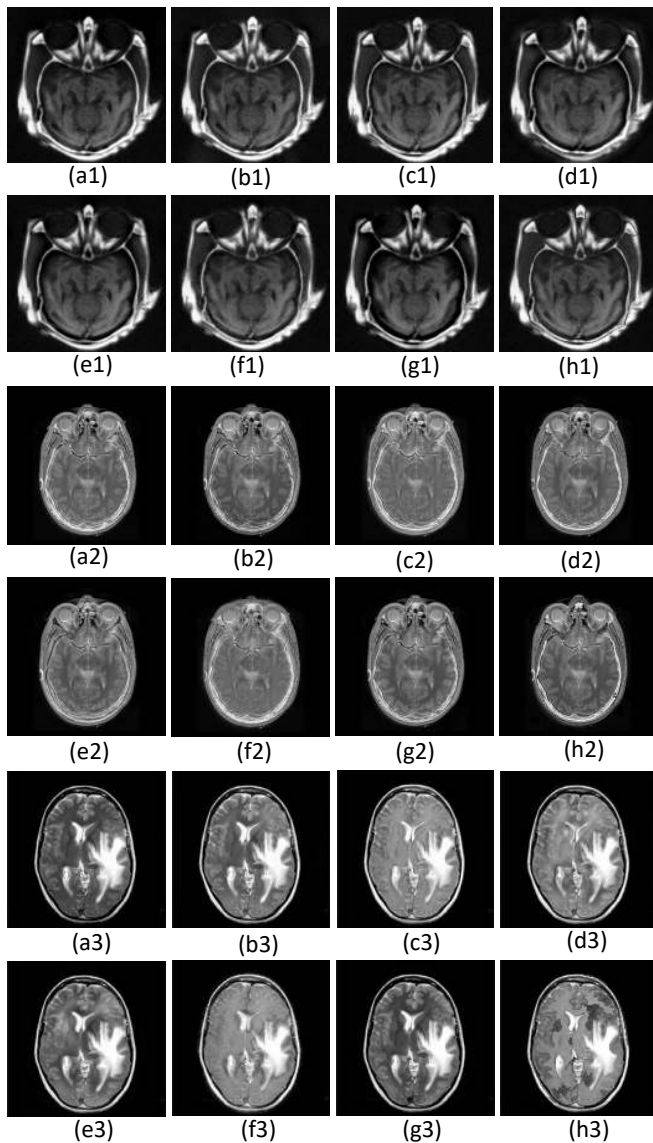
Three pairs of CT-MRI medical image fusion results of eight different image fusion methods. Fused images (a1), (a2), (a3) is LP-SR based method; (b1), (b2), (b3) CNN based method; (c1),(c2),(c3) CFL based method; (d1), (d2), (d3) NSST-PAPCNN based method; (e1), (e2), (e3) NSCT-PC-LLE based method; (f1), (f2), (f3) LRD based method; (g1), (g2), (g3) NSCT-SR bAsed method; (h1), (h2), (h3) the proposed method.
